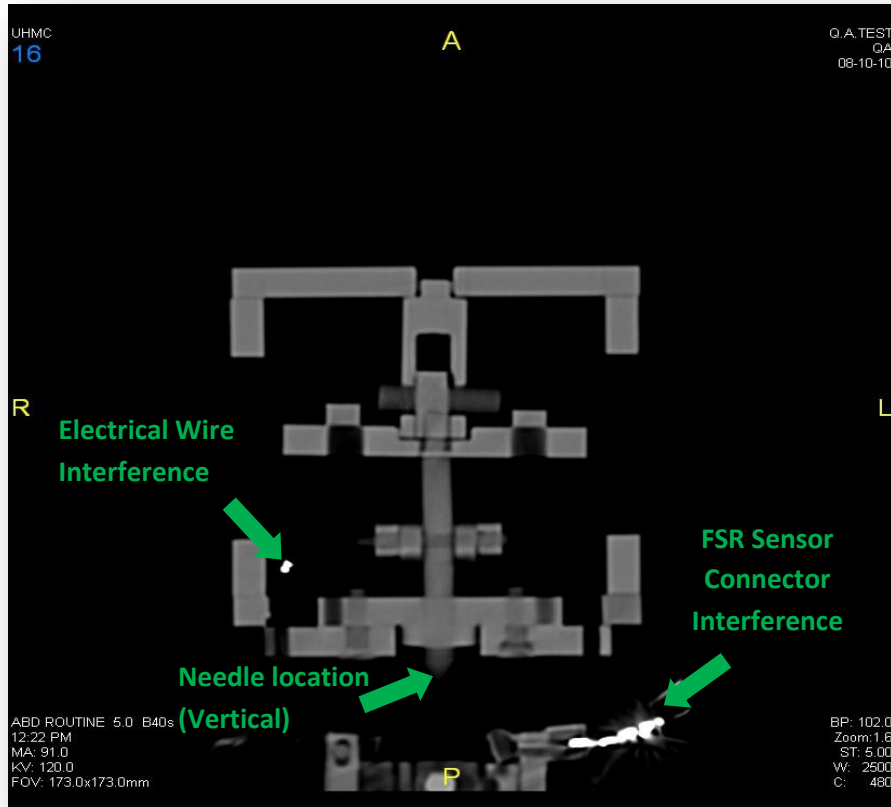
CT preview scan of the prototype in the top view.
